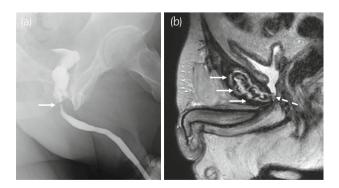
Radiological findings of case 2. (a) Retrograde urethrography showed VUAS (arrow). (b) T2-weighted MRI in the sagittal plane showed a fistula arising from the vesicourethral anastomosis site (dotted arrow) to the pubic symphysis (arrows).
